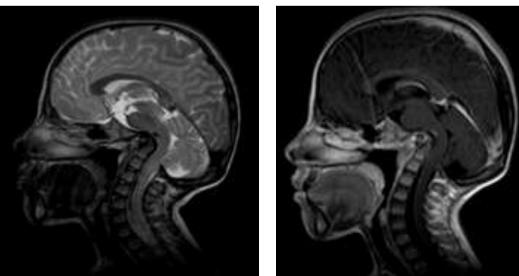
Osteogenesis imperfecta: Sagittal T1(Right) and T2(Left) weighted MR images showing basilar invagination with odontoid process in foramen magnum, platyspondyly, cervical cord compression.
